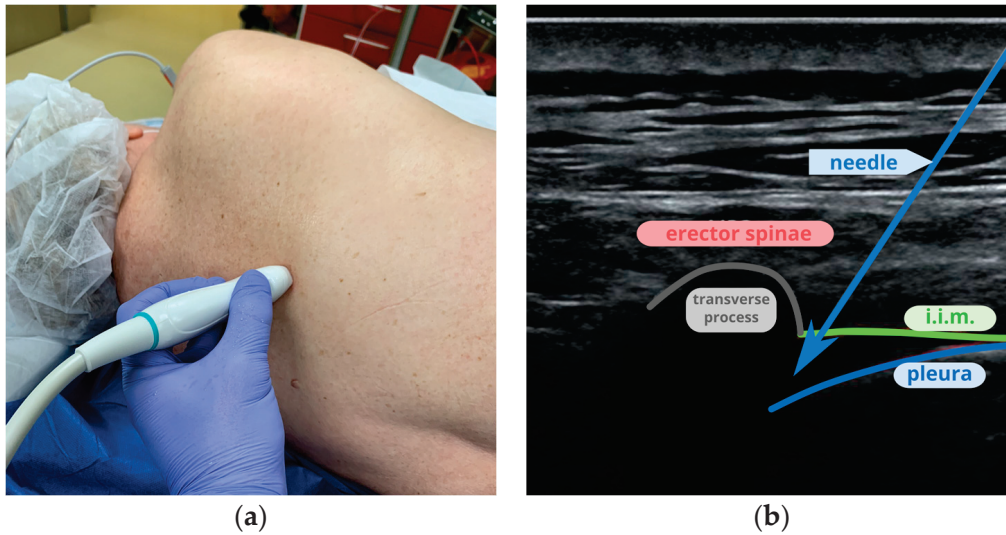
Paravertebral block: (a) placement of the probe between the fourth and fifth ribs for PVB; (b) an ultrasound image of the costotransverse joint and internal intercostal membrane (i.i.m.).
